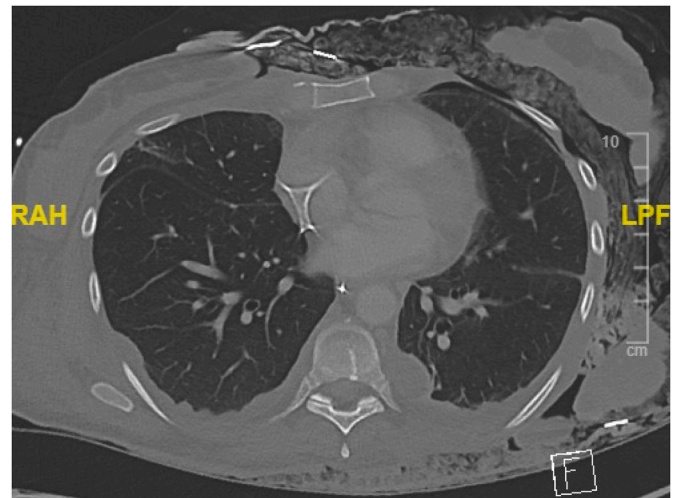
Chest CT scan showing the extension of the tissue lesion and the pneumothorax.
